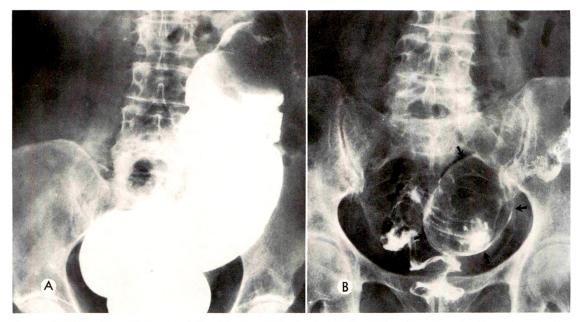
(A) An obstructing smooth bordered mass in the descending colon is seen on barium enema study. (B) The size, contour and shape of the mass are well demonstrated in the postevacuation roentgenogram.
